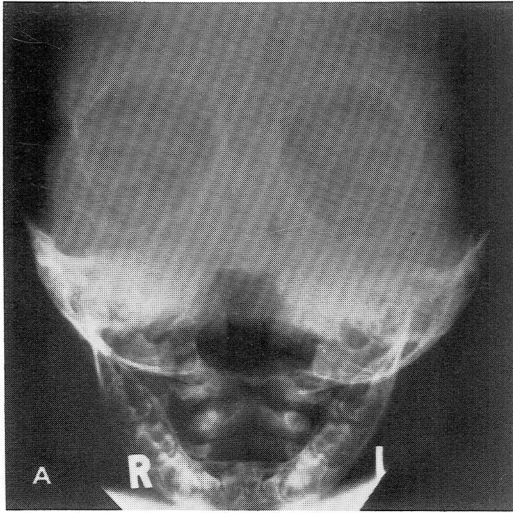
Patient 2. Frontal roentgenogram demonstrates similar radiological features as in Patient 1. Orbital Hypotelorism, microcephaly and hypoplasia of median facial bones are present. Longest diameter of the orbits are convergent superomedially.
